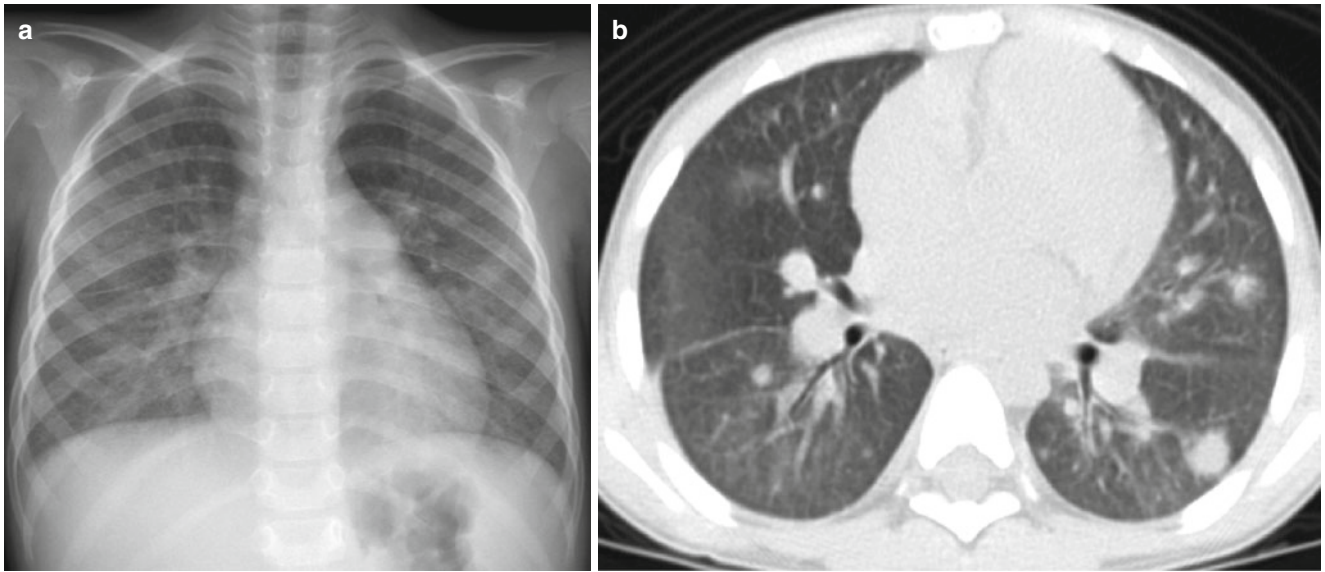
A 5-year-old boy with confirmed invasive aspergillosis disease. Chest radiograph (a) is nonspecific but suspected nodules are seen on the left lung. Axial CT image (b) confirms the presence of non-calcified pulmonary modules in both lungs
